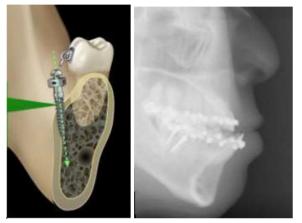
Extra alveolar site of placement of MBS bone screws radiograph showing its angulation
